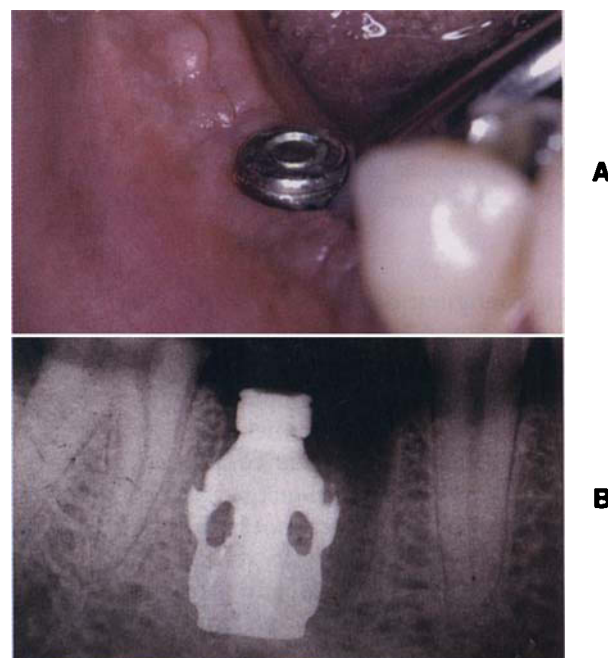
■ Intraoral view (A) and radiograph (B) of two-stage plate/blade form with healing collar inserted within recent molar extraction site.
